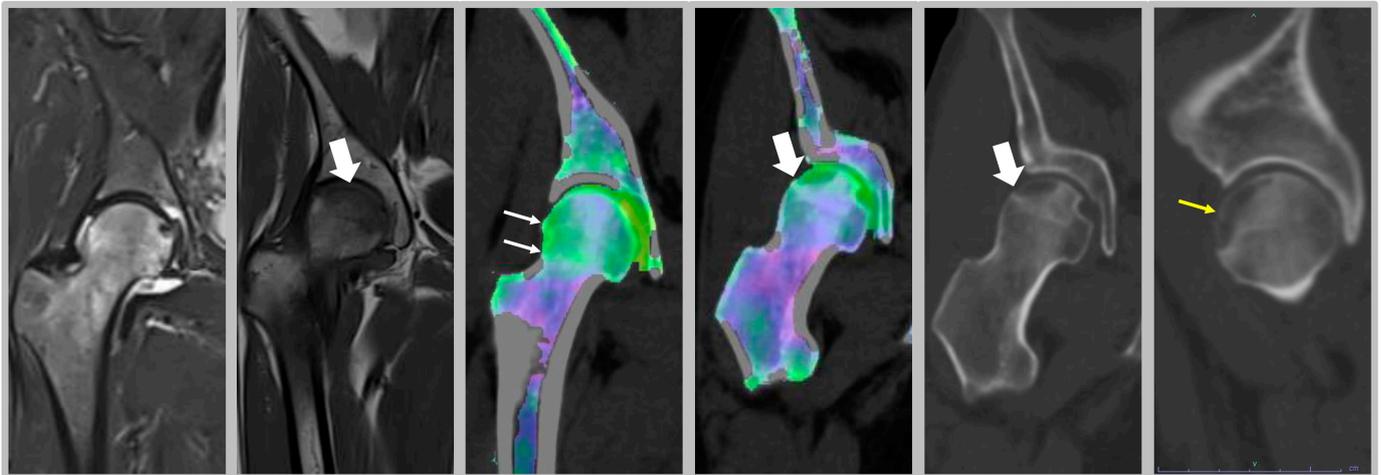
Clinical cases of nonprofessional runner. Female nonprofessional runner, 38 years old. MRI images in STIR show transient edema; T1 images (thick arrow) show small irregularity of cortical bone profile. Dual energy CT confirms the edematous pattern of the right femoral head, with BME appearing green against a purple background of normal bone (thin arrow). However, the edema appears more conspicuous in the subchondral area, where a large hypodense area appears on the partition images, with a small subchondral fracture well confirmed on the coronal (thick arrow) and sagittal (yellow arrow) reconstructions.
